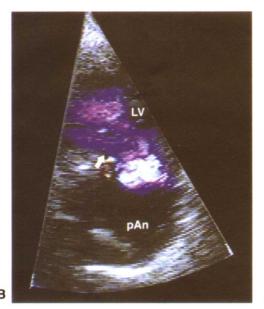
A,经食管超声心动图清楚的显示升主动脉。B,彩色血流 Doppler 显示联合主动脉瓣反流。C,胸降主动脉短轴观 显示真腔(TL)和假腔(FL)之间的沟通,二者由内膜瓣(箭头)分割
